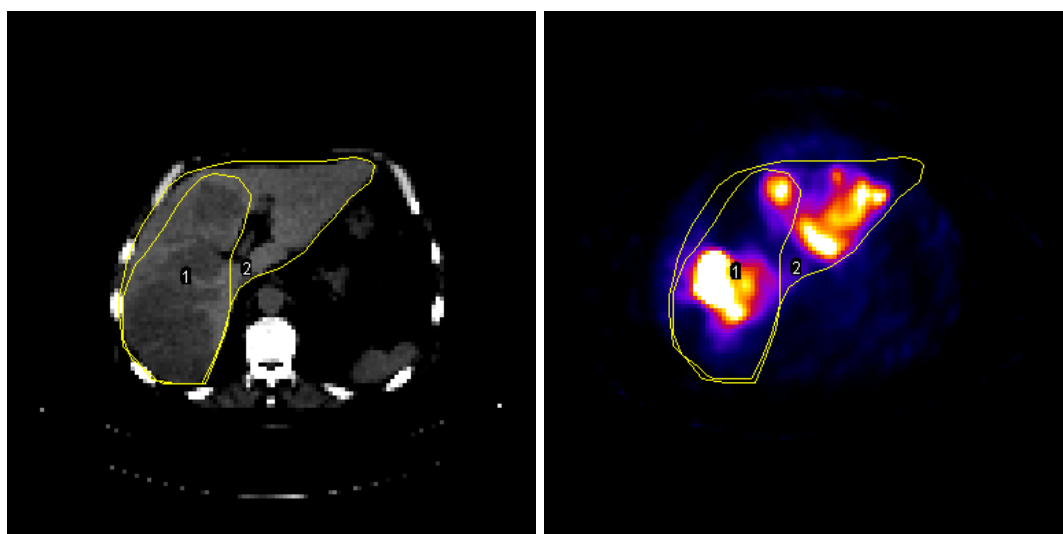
Representative axial SPECT image to calculate the T/N ratio. CT and  $^{99\text{m}}\text{Tc}$ -MAA/SPECT images with ROI surrounding the entire liver and the treated tumor.
